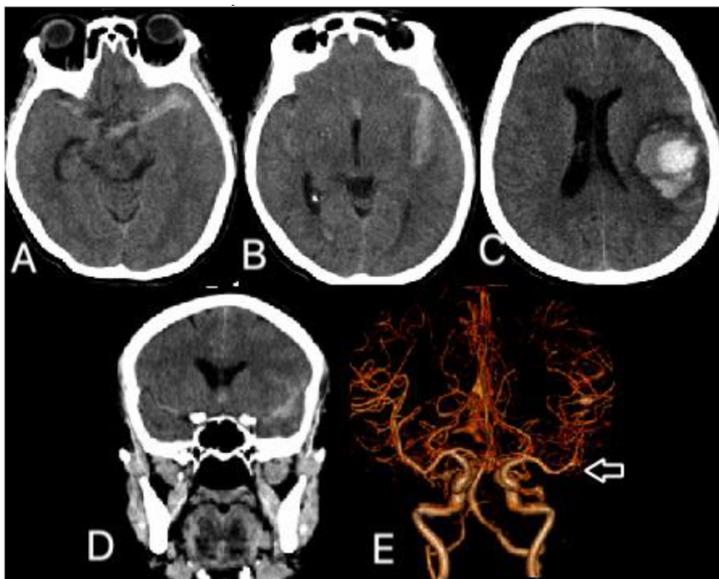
Results of CT scan for head angiography of second case. A. Minimal SAH in the frontal interhemispheric fissure, while in the sylvian fissure, the right and left basal cisterna, the left and right ambient cisterna, and the left and right suprasellar cisterna. B, C. Left and right lateral ventricular IVH and III. D. Saccular aneurysm in the internal carotid artery of the supraclinoid sinistria.
